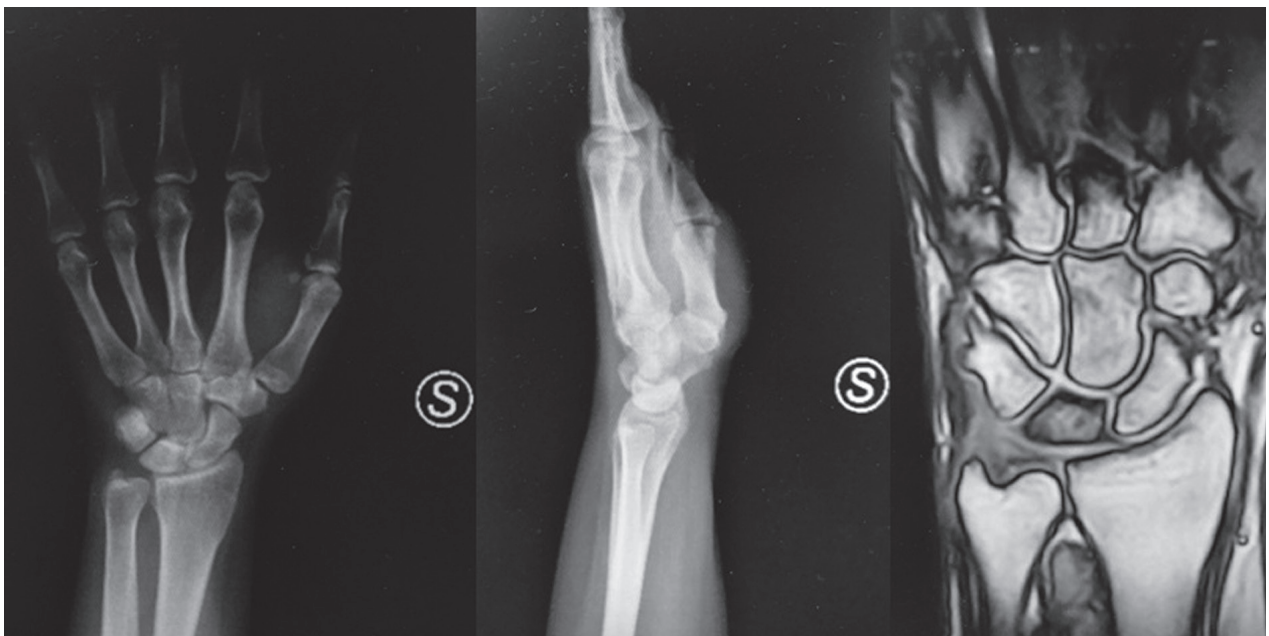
X-Ray and MRI images preoperative
